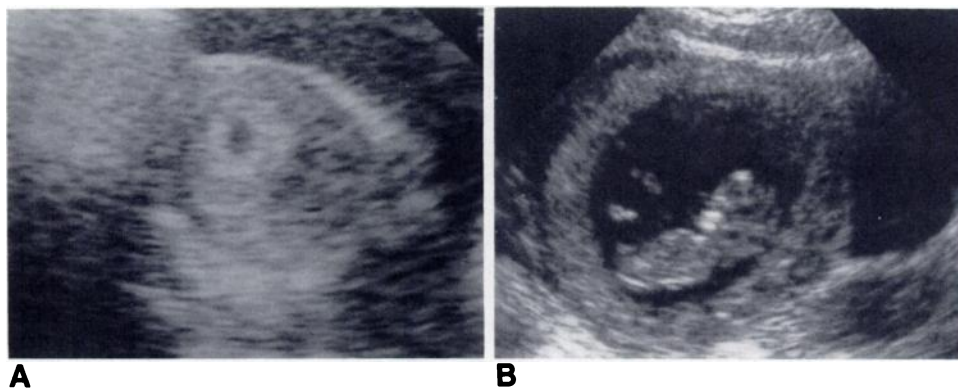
A, Transverse real-time sonogram. Intrauterine sac measures 10 mm in mean sac diameter. Maternal serum HCG level obtained same day was 3647 mIU/ml. Presence of double decidual sac, comprising two concentric echogenic rings, confirmed this sac to represent true gestational sac. B, 6 weeks later. Living fetus is shown.
